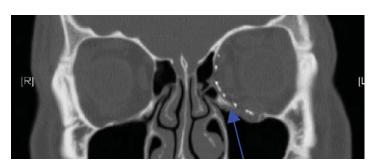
Preoperative coronal and axial computed tomography views of patient (Case 7) with a combined medial orbital wall and floor fracture affecting the left orbit.
